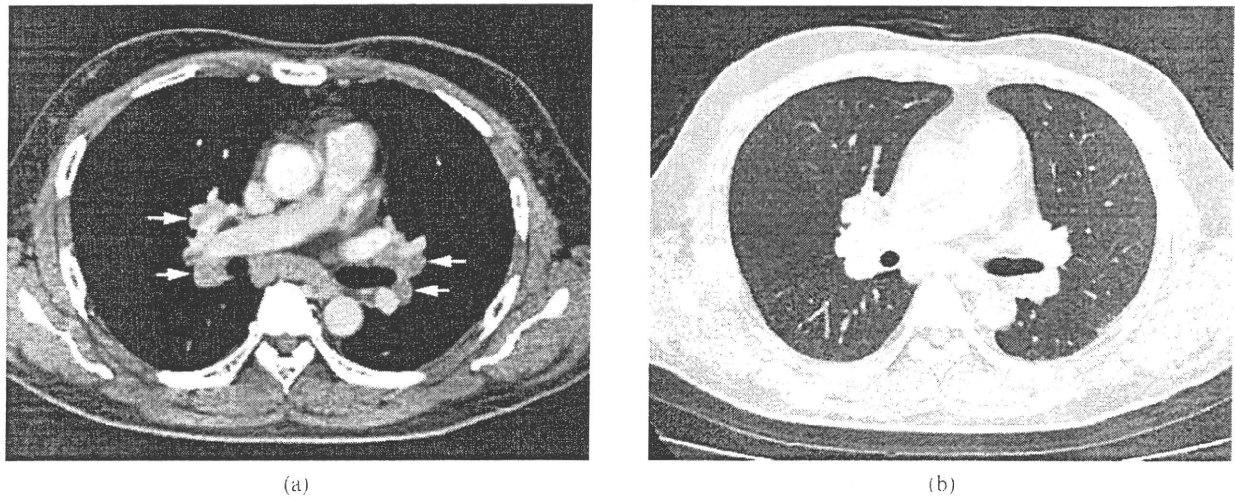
Images in a 46-year-old male (KL-6, 239 U ml⁻¹) (a) Transverse CT scan (1 mm section thickness) obtained at the level of the right pulmonary artery shows enlarged lymph nodes at subcarinal and bilateral hilar regions (arrows). (b) Transverse CT scan (1 mm section thickness) obtained at the level of the pulmonary artery shows no abnormal parenchymal lesions.
